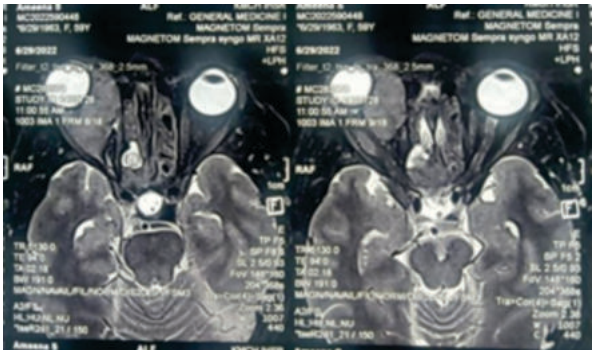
Axial MRI Scan of the Orbit Showing Retro-Orbital Mass
